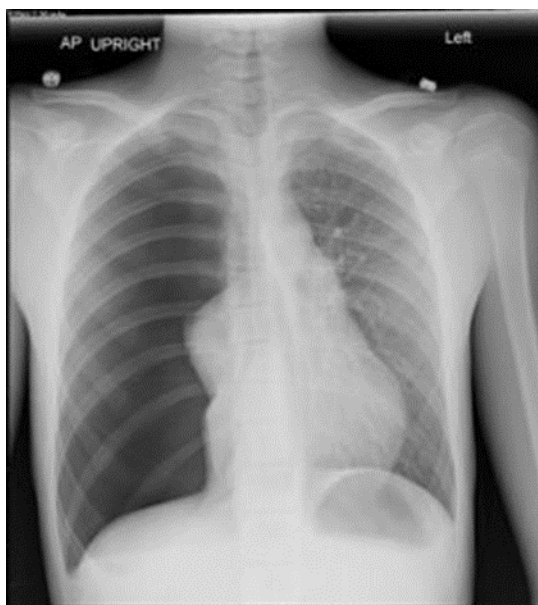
A chest X-ray of a patient with a large right pneumothorax
